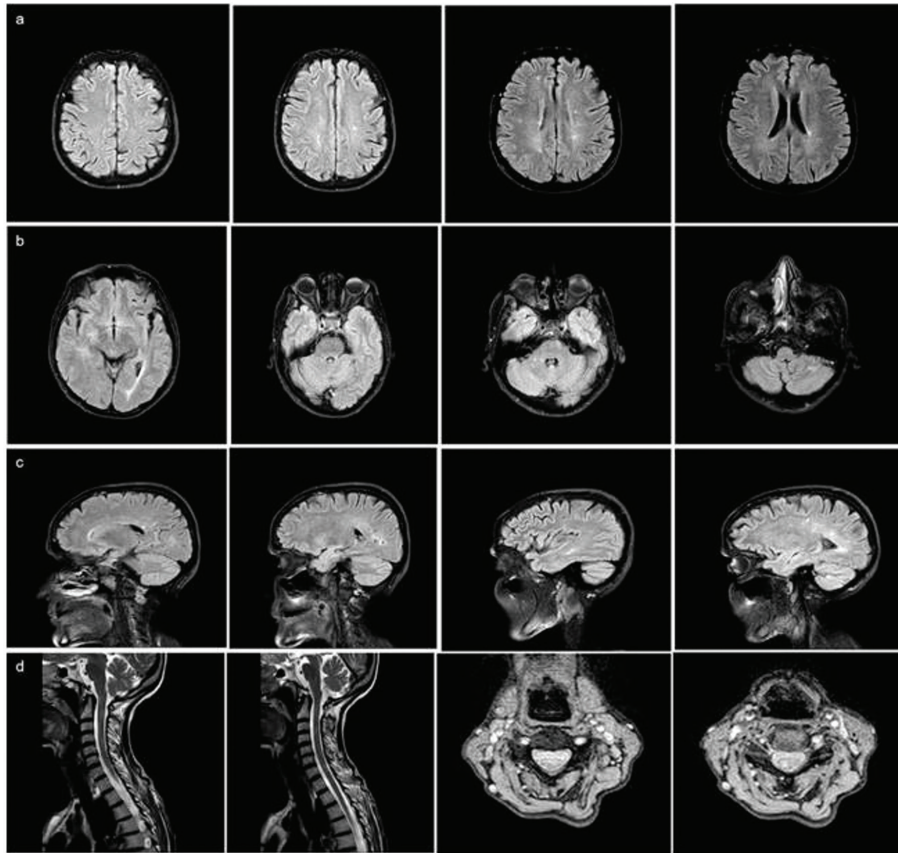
(a, b) Axial and (c) sagittal FLAIR sequences and (d) sagittal-axial T2-weighted magnetic resonance images of the cervical spinal of a patient. Periventricular, cerebellar, pontine and cervical spinal demyelinating lesions are observed
